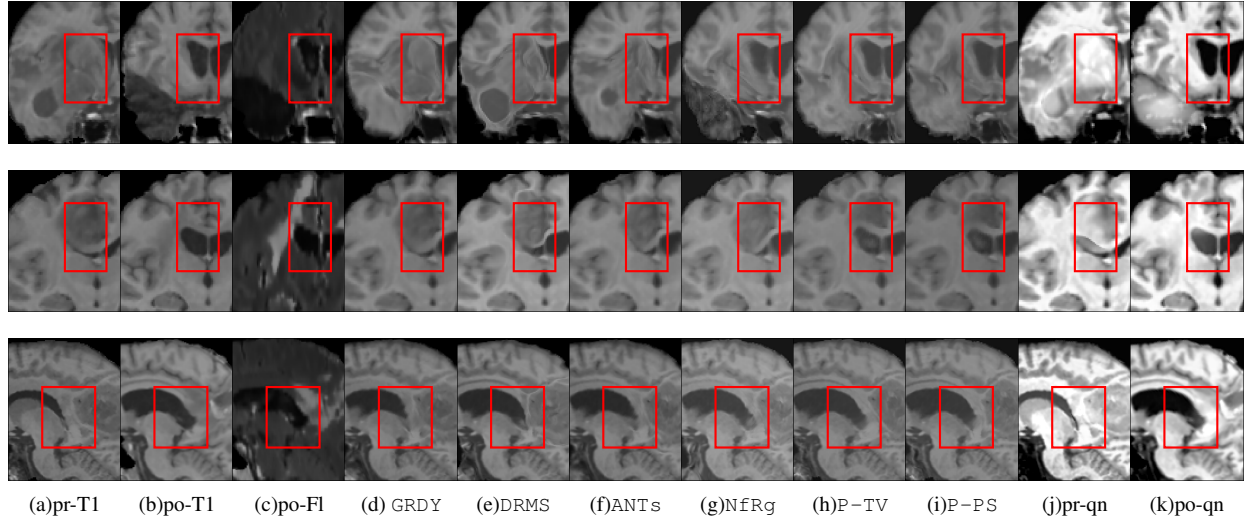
Example registration results from three patients. (a) and (b) show the *pre* and the *post* T1 scans. (c) shows the *post* T2-FLAIR scans, only for visualization purposes. (d)-(i) show registration results of *pre* to *post* from GREEDY, DRAMMS, ANTs, NiftyReg, PCA-TV, and the proposed patient-specific model, PCA-PS. In addition, (j) and (k) show the quasi-normal reconstructions of the *pre* and *post* scans, respectively. The red box highlights major differences.
